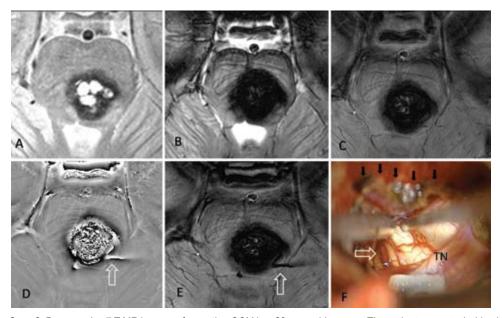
Case 2. Preoperative 7-T MR images of a pontine CCM in a 29-year-old woman. The patient presented with a hemihypesthesia of the left half of the face and the right half of the body, and a mild motor weakness. The CCM was fully removed using a left subtemporal transtentorial approach. Comparison of T2-weighted turbo spin echo (A), T2\*-weighted gradient echo (B), and susceptibility weighted (C-E) imaging at the same brain level. In the phase image (D) and in the processed susceptibility weighted image (E), a curved draining vein can be seen (white arrows), which was identified intraoperatively (F). In the T2\*-weighted gradient echo (B) and in the magnitude (C) images, as well as in the routine preoperative contrast-enhanced T1-weighted turbo spin echo, this vessel structure could not be delineated. The T2-weighted turbo spin echo (A) is showing the typical popcorn-like aspect of the CCM, representing different stages of microhemorrhage. The rather acute hemorrhages lead to stronger intralesional signal cancellations in the T2\*-weighted gradient echo and susceptibility weighted images. TN = trochlear nerve. Small black arrows denote the incised tentorium.
